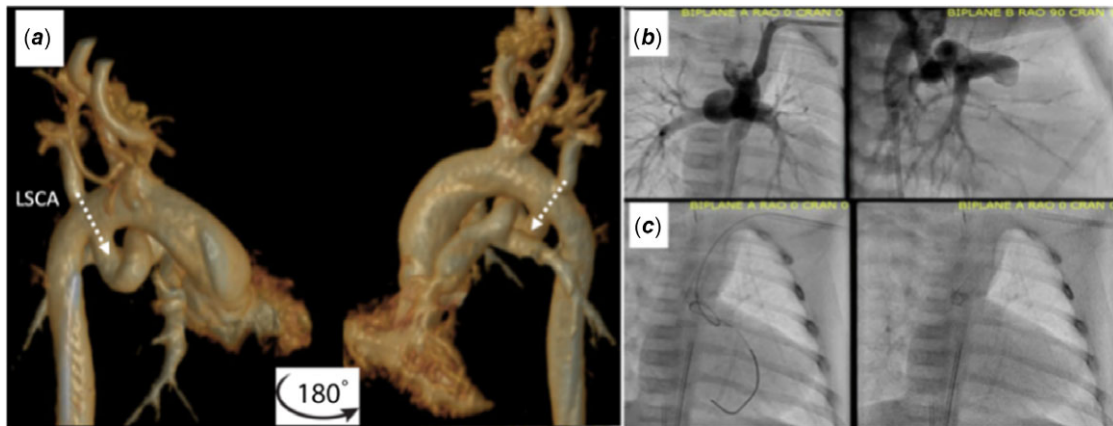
Neonatal PDA stenting approach and procedure. (a) Pre-procedural cardiac CT 3D reconstruction showing a “corkscrew” PDA. (b) Patient was approached via the left axillary artery (LAA) to left subclavian artery (LSCA) for PDA stenting. (c) Successful delivery of a 3.5 mm × 23 mm Vision Multilink stent.
